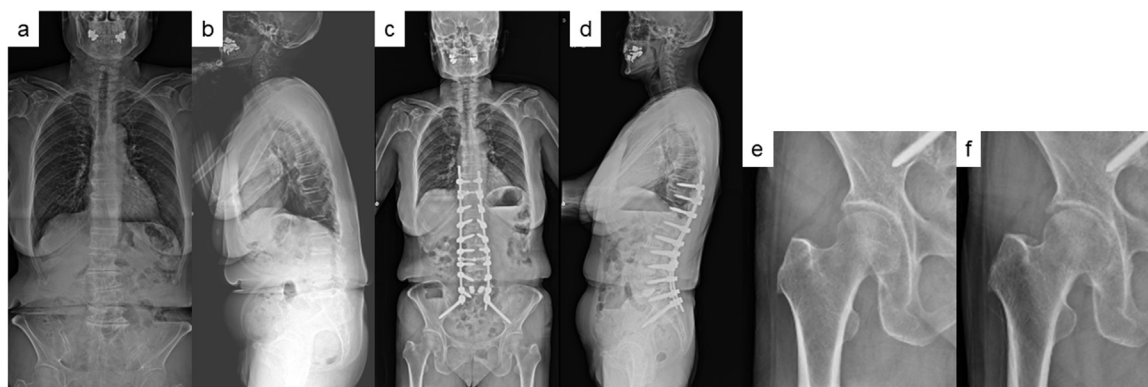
Representative case. A 76-year-old woman underwent spinopelvic corrective fusion surgery from T10 to the pelvis. There was no hip lesion 1 month after surgery, but she experienced right hip pain 5 years later. A standing X-ray showed that the joint space had decreased and the KL grade had progressed for 5 years.
